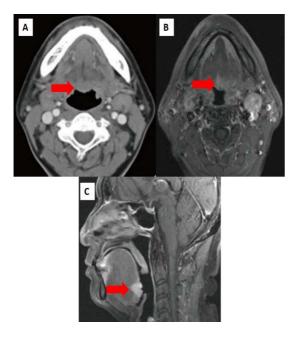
IMAGING FINDINGS: A well-defined soft tissue density lesion, homogeneously enhancing on post contrast MRI image (3B, 3D) is noted centred on base of tongue (not depicted on CECT (3A), but clearly depicted on corresponding MRI image)
